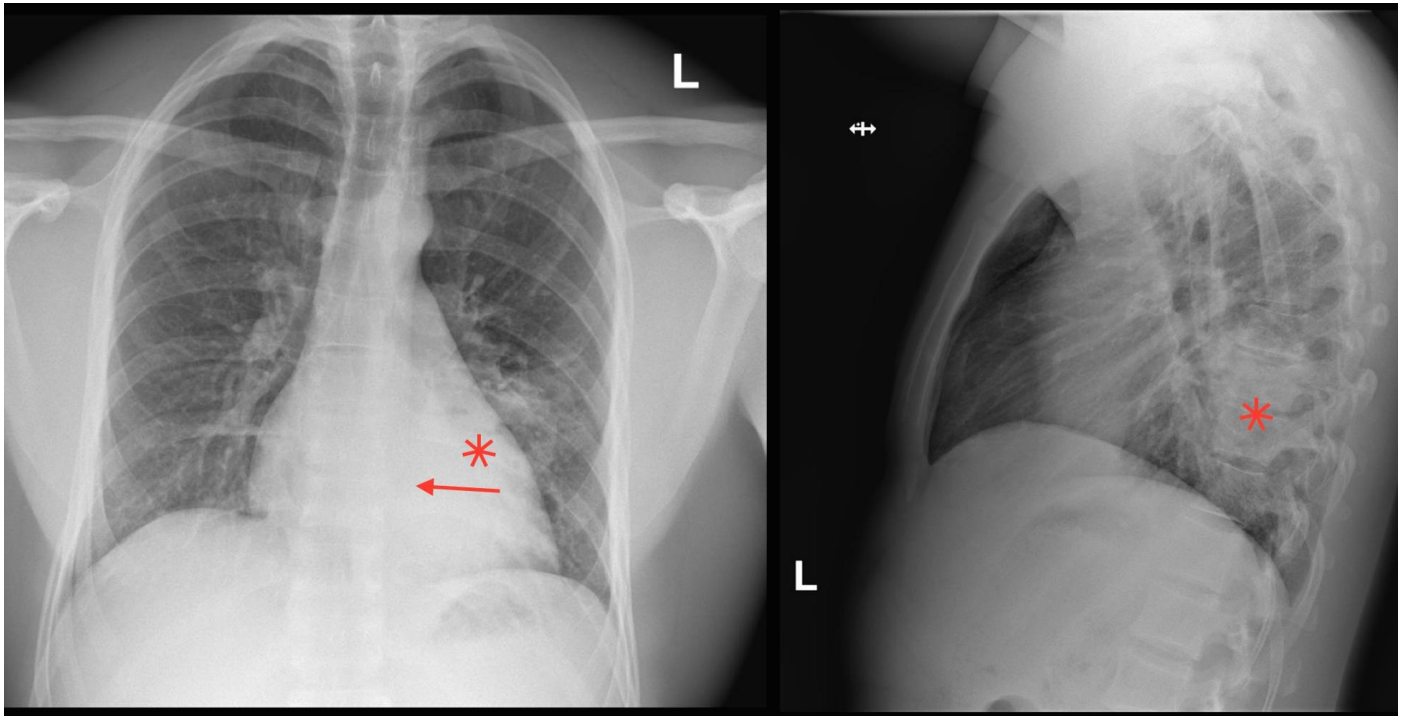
23 year old male with post obstruction pneumonia due to mucoepidermoid carcinoma of the airways. Technique: plain PA and lateral radiograph (Siemens. 0,2 mm CU filter. PA:125 kV; 2,7 mAs. Lateral: 125 kV; 16,5 mAs). Findings: Consolidation in the left lower lobe (red asterisks) with silhouette sign of the descending thoracic aorta (red arrow).
